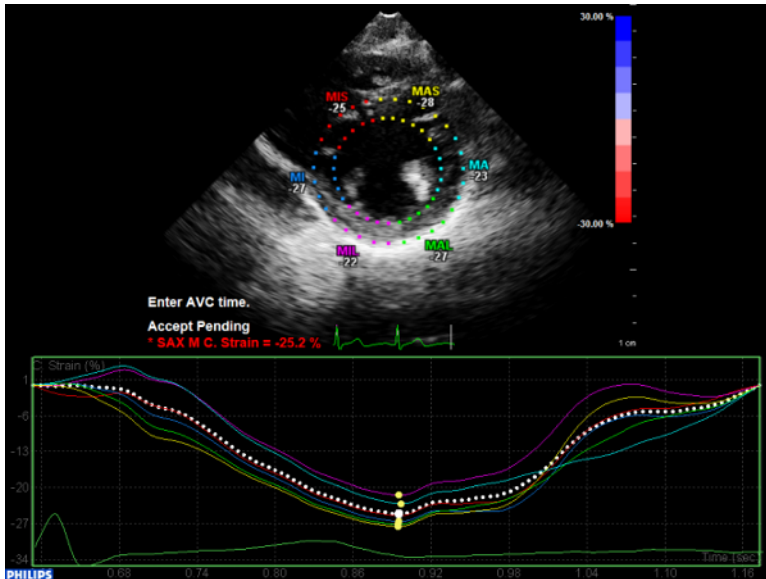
LV circumferential strain. Parasternal short axis view at the level of the papillary muscles yields circumferential ϵ . The myocardium is subdivided into six segments. Regional peak LV circumferential ϵ values are displayed at the top. Segmental colors correspond to the time-strain curves displayed at the bottom. The white dotted line represents global circumferential ϵ . Note the smooth and parallel shape of the segmental and global time-strain curves. [Please click here to view a larger version of this figure.](#)
